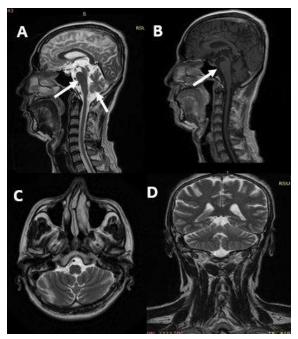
MRI of the Head (1.5 Tesla) (A) Sagittal T2 weighted (B) Sagittal T1 with contrast showing slight pons and cerebellar atrophy (white arrow) (C) Axial T2-weighted (D) Coronal T2-weighted shows folia cerebellum which is prominent
